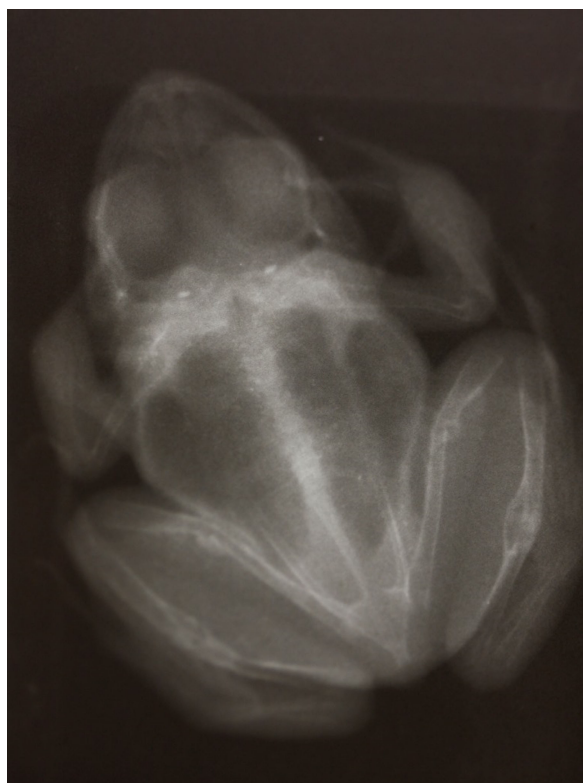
Radiograph of an 8-month-old captive bred mountain chicken (*Leptodactylus fallax*) at Durrell Wildlife Conservation Trust initially reared without UV-B. UV-B was provided at 6 months of age and bone mineralization had improved but bone deformities remain.
